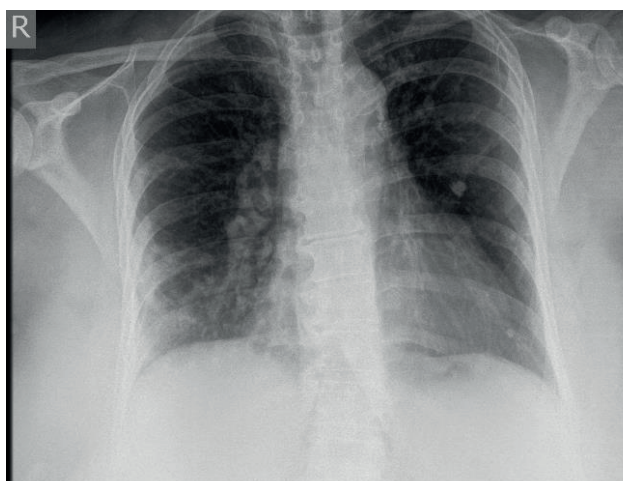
Chest X-Ray–bilateral lung infiltration
